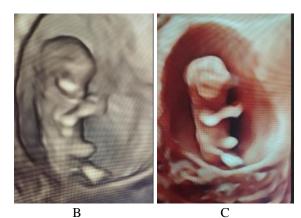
A, B, C. 2D, 3D and HD ultrasound images of a 10weeks 4days fetus showing physiological herniation.
